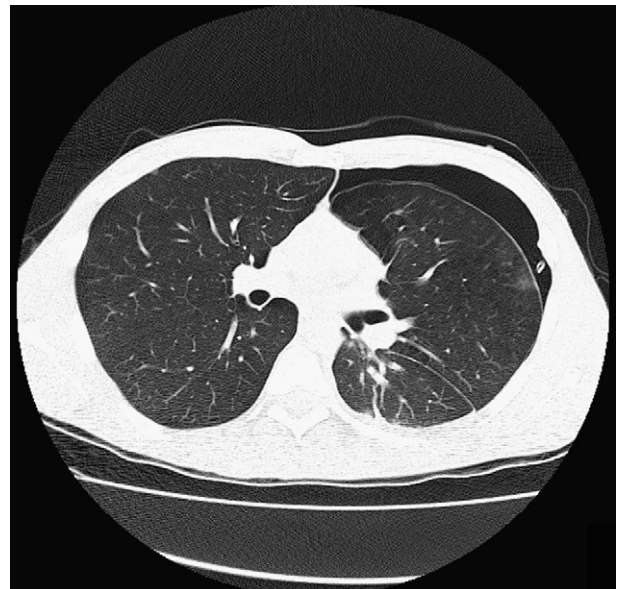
High resolution CT scan of chest showing apical bullae and a non-resolving pneumothorax with a well sited drain.
